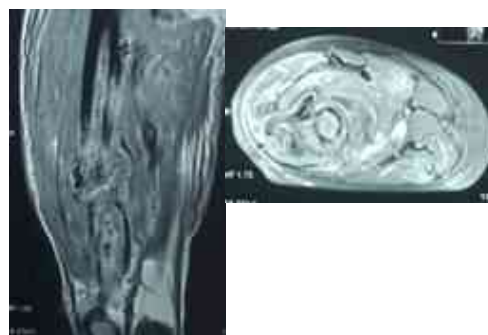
MRI of femur of the 2nd patient.
